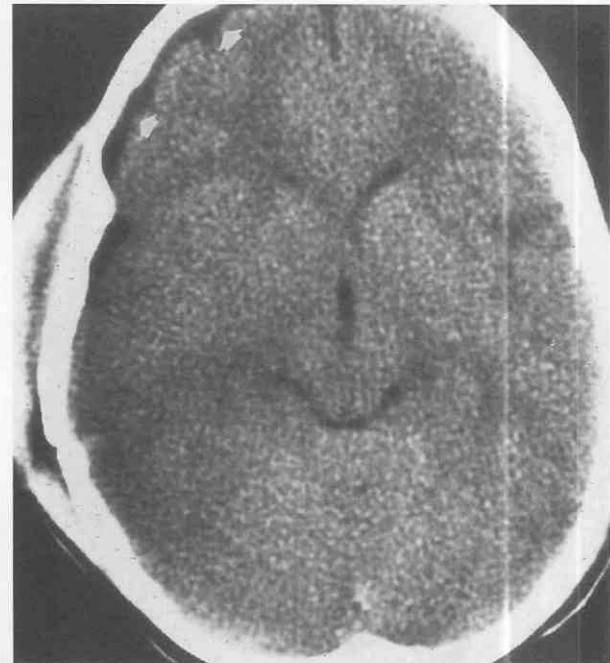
Cerebrospinal fluid-density collection representing a cerebrospinal fluid hygroma is present over the right frontal convexity (*arrows*). The initial CT scan 3 days earlier showed no subdural collection.
